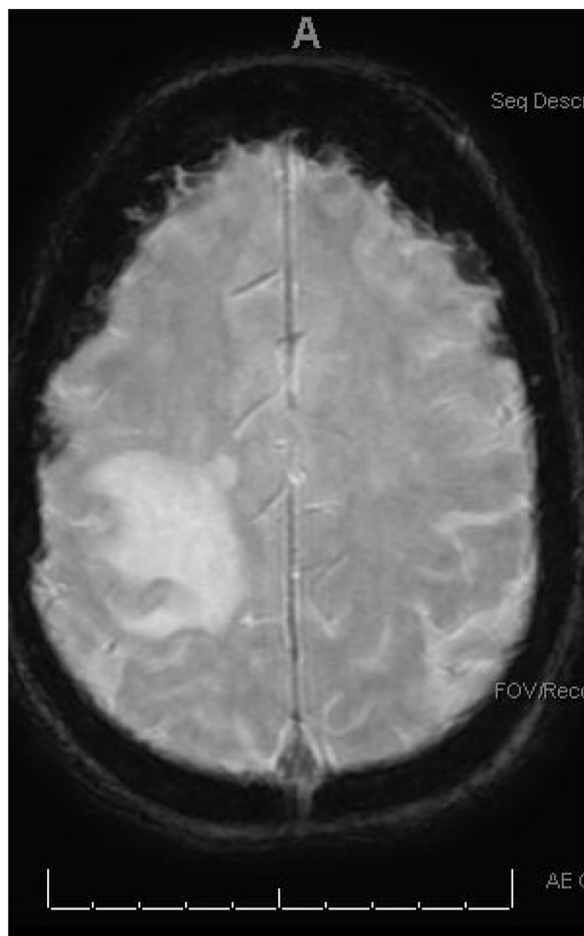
MRI of the right frontal parietal 1.2 cm mass concerning for malignancy and metastatic disease.
